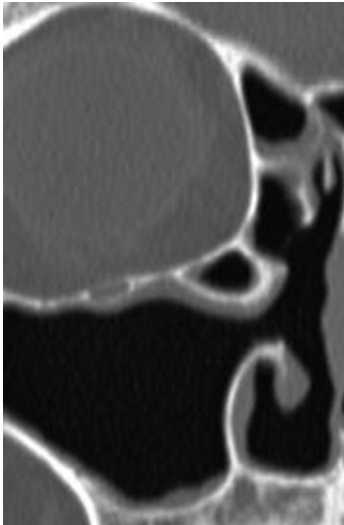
This right sided “Haller” (infraorbital ethmoid) cell is seen on the coronal sinus CT scan of a patient who had previous sinus surgery. Because of its location, it blocked the natural sinus opening from the original surgeon’s view and required a second surgery to remove this cell so that the natural opening could be connected to the surgical opening for the sinus to drain freely.
